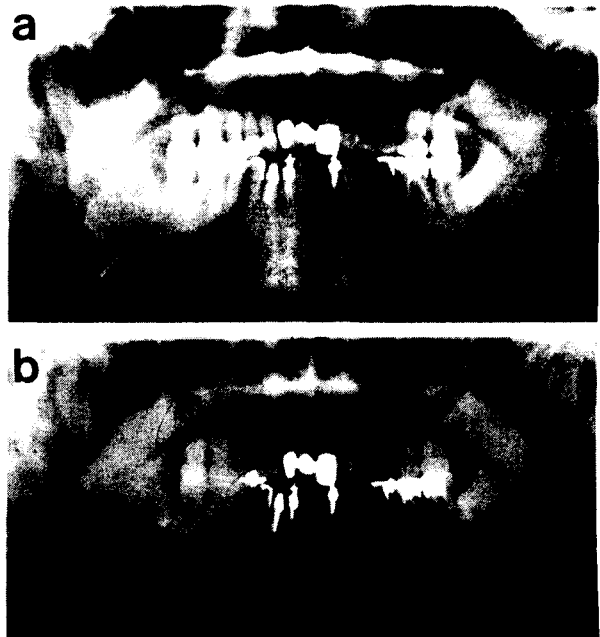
Orthopantomogram showing fracture line extending from the third molar to the mandibular angle (a), but fracture line is not evident 3 days later (b).
